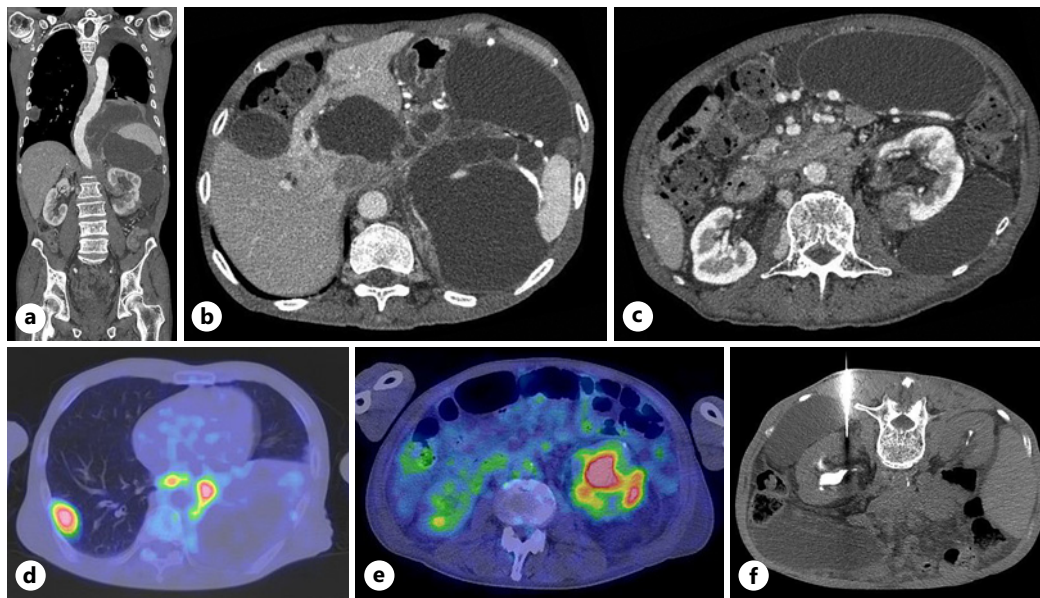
Coronal image (a) and axial images (b, c) showed a large multilocular cystic tumor which extended under the diaphragm into the pelvis and surrounded the left kidney and spleen. The right lung mass (d) and the soft tissue structures in the retroperitoneal cystic tumor (e) were strongly enhanced by FDG-PET. CT-guided percutaneous biopsy-targeted left perirenal soft tissue structure was undertaken in prone position (f).
